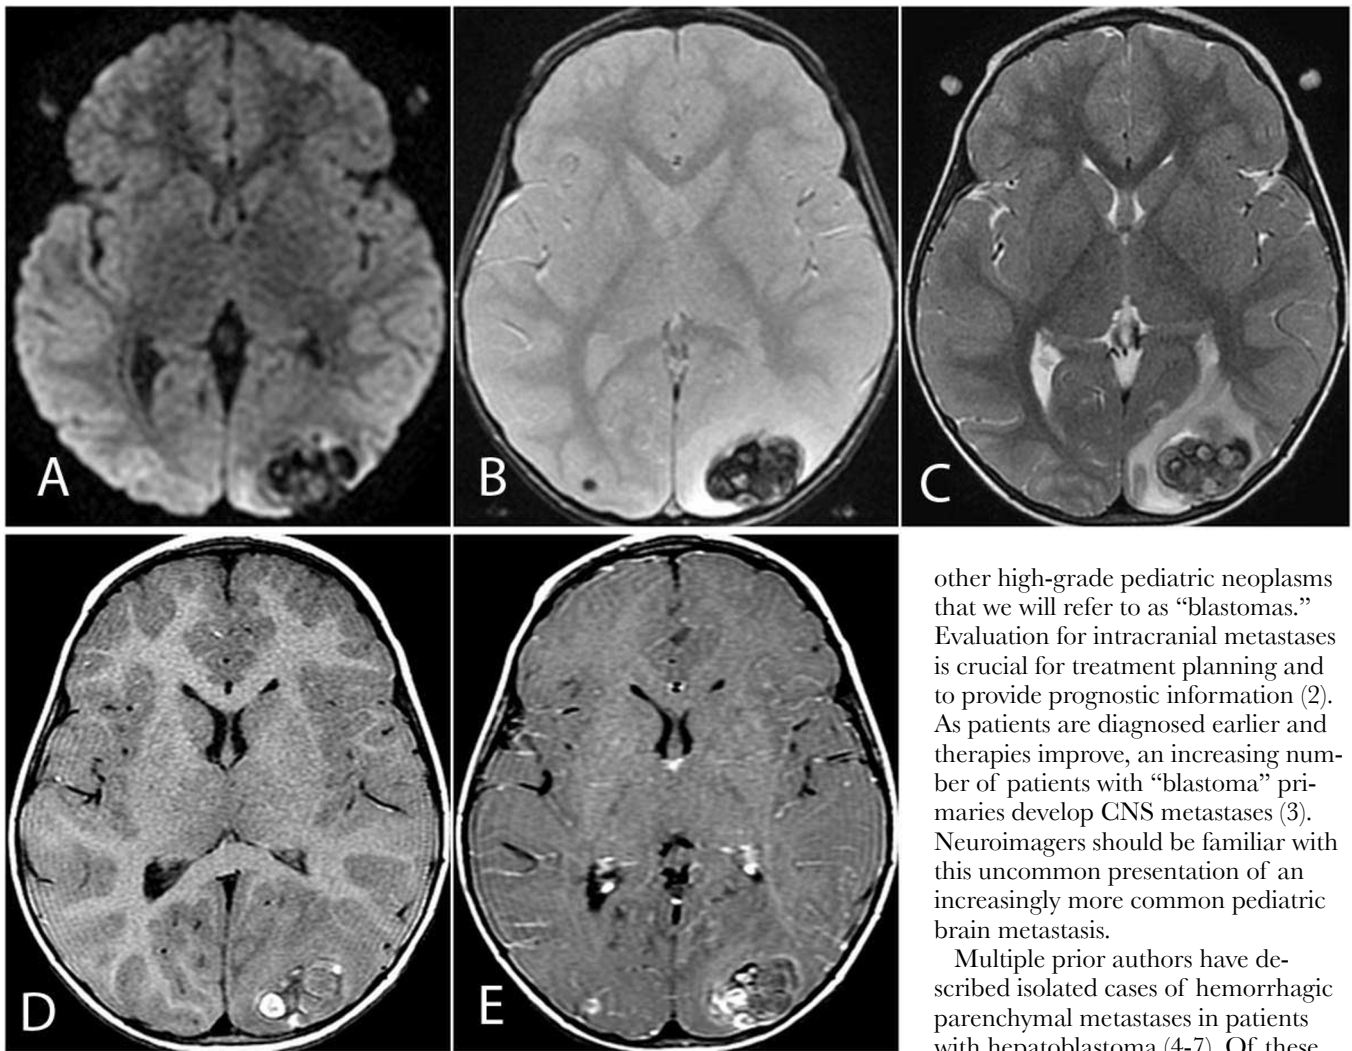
4-year-old girl with hepatoblastoma. Initial MRI performed from the emergency department (A-E) demonstrating multiple lesions containing acute and subacute hemorrhage and minimal, if any, contrast enhancement. DWI (A) demonstrates no reduced diffusion associated with the lesion to suggest hemorrhagic infarct. MPGR (B) demonstrates bosselated hemorrhage within the dominant lesion in the left occipital lobe. Of note, a second hemorrhagic lesion is also present in the right occipital lobe. Axial T2WI (C) demonstrates hemorrhage of varying degrees of T2 intensity, consistent with hemorrhage of different chronicity. Surrounding vasogenic edema in the white matter may be indicative of acute hemorrhage, or edema secondary to an underlying mass. Axial T1WI (D) and after contrast (E) demonstrate minimal if any enhancement and intrinsic T1 shortening consistent with hemorrhage.
